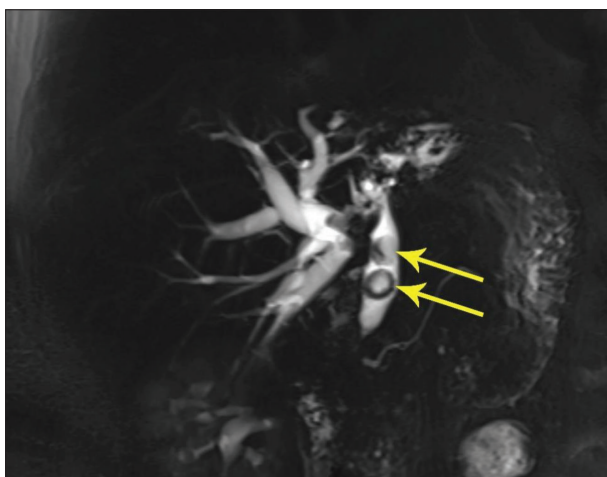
Preoperative magnetic resonance imaging of the abdomen; stones in the main bile duct are marked with yellow arrows
